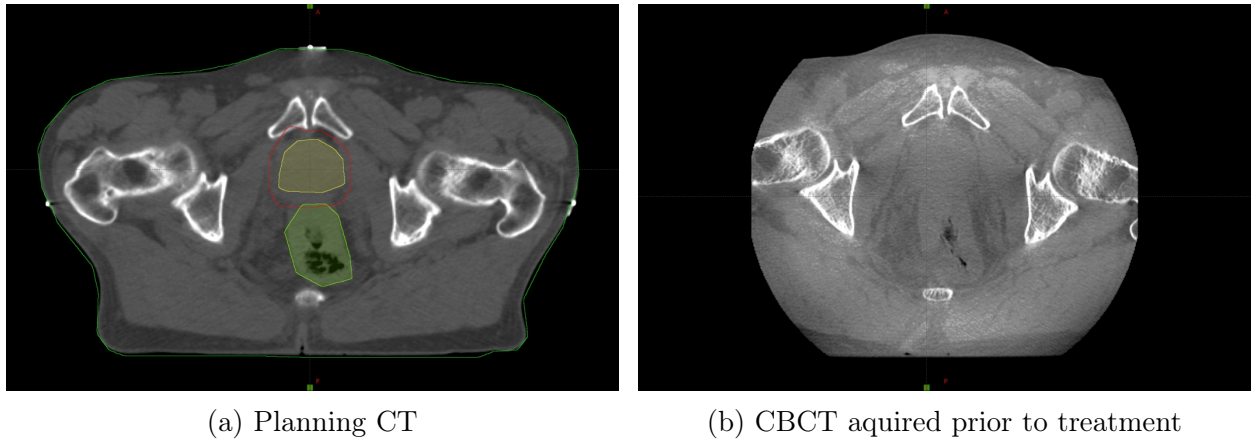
Comparison between planning CT and CBCT. Structures seen on planning CT are: yellow – CTV, red – PTV, green – rectum. Scans were taken in the Maria Skłodowska-Curie Institute — Oncology Center in Warsaw.
